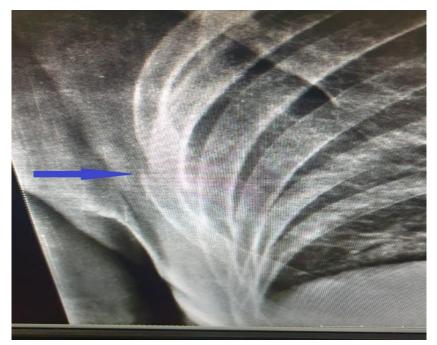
Rib fracture seen in X-ray Chest (Before treatment).
